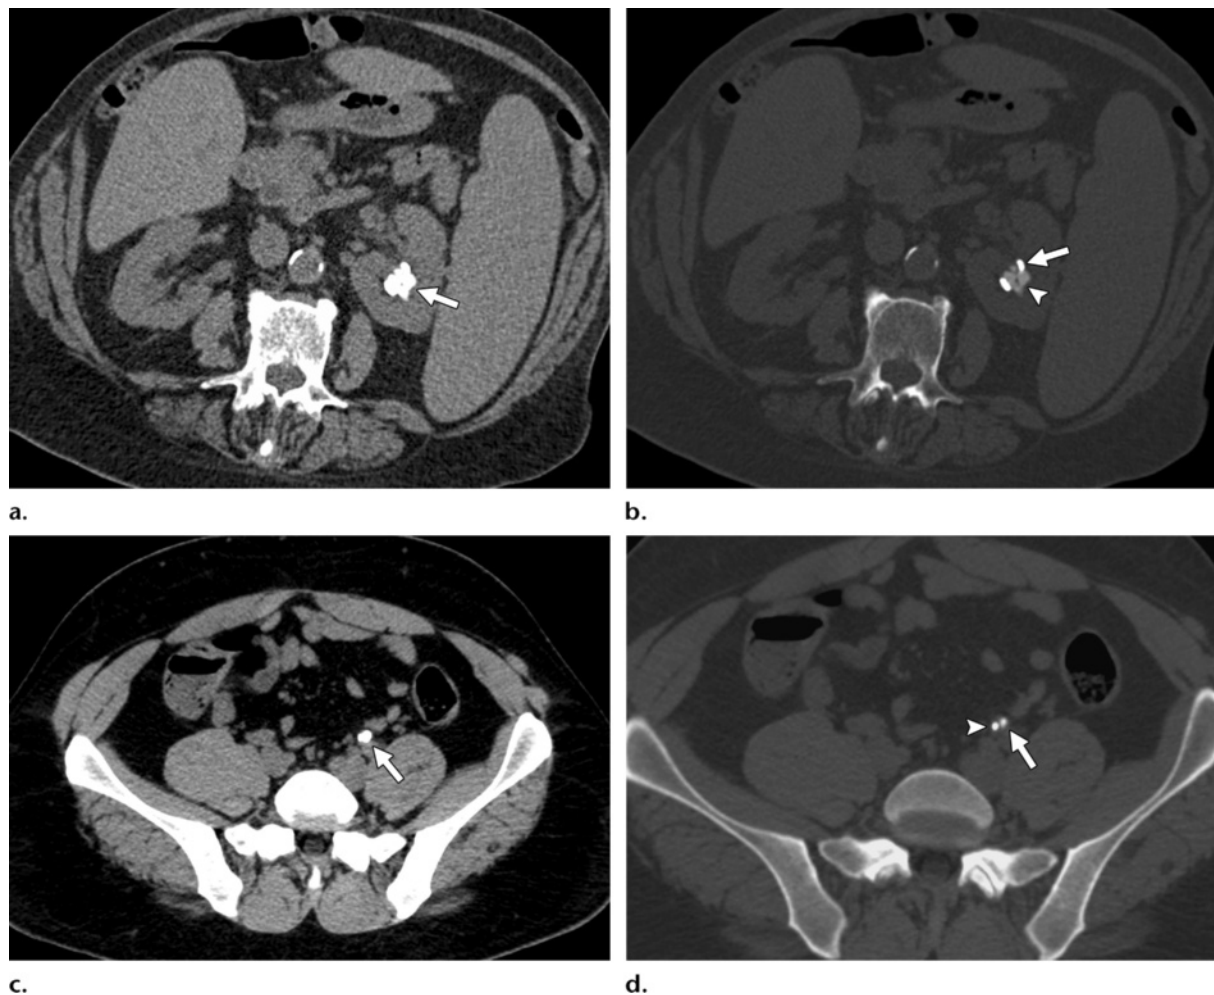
Ureteral stents. (a) On an axial unenhanced multidetector CT scan (abdominal window settings [window width HU/window level HU = 400/30]), the proximal portion of a stent (arrow) is indistinguishable from renal pelvic stones. (b) On an axial CT scan (bone window settings [1120/300]), the stones (arrowhead) can be clearly distinguished from the stent (arrow). (c) Axial CT scan (abdominal window settings [400/30]) obtained in a different patient following ureteral stent placement shows a stent in the midureter (arrow). (d) CT scan (bone window settings [1120/300]) shows a 4-mm calculus (arrow) adjacent to but distinct from the stent (arrowhead).
